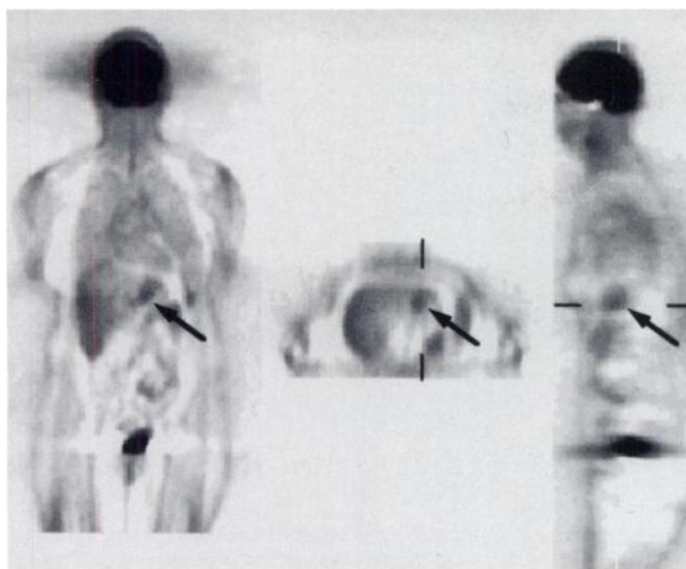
A 56-yr-old woman with increased CEA and CA 15-3, 2 yr after surgery. An abdominal CT scan was negative. FDG-PET was done 7 days after the abdominal CT scan. Coronal FDG-PET scans showed increased uptake in the left lobe of liver. A liver biopsy confirmed the metastatic breast carcinoma.
